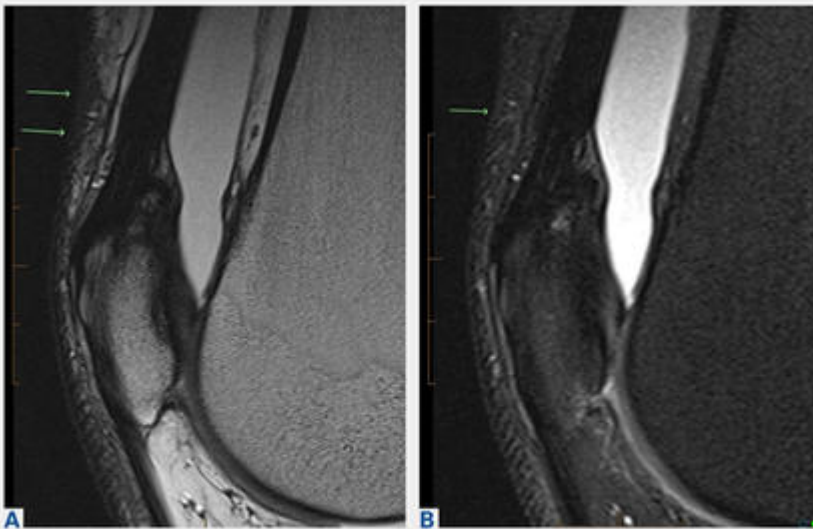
Six-month follow-up magnetic resonance imaging of the left knee. (A) Sagittal proton density and (B) T2 fat-saturated images show resolution of the fluid defect in the suprapatellar subcutaneous fat with a 15-mm longitudinal, low signal distortion/scar and mild fatty atrophy (arrows) of the suprapatellar fat corresponding to a healed fat fracture. A new incidental small effusion also is shown.
